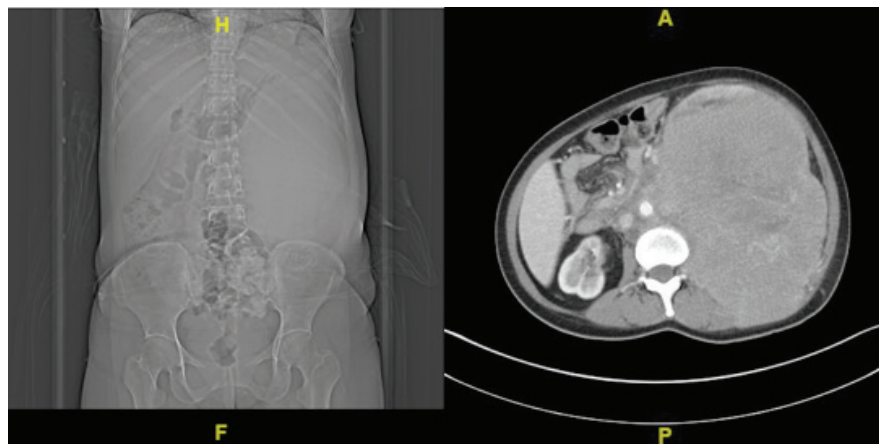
CT Abdomen with Contrast in Second Patient
